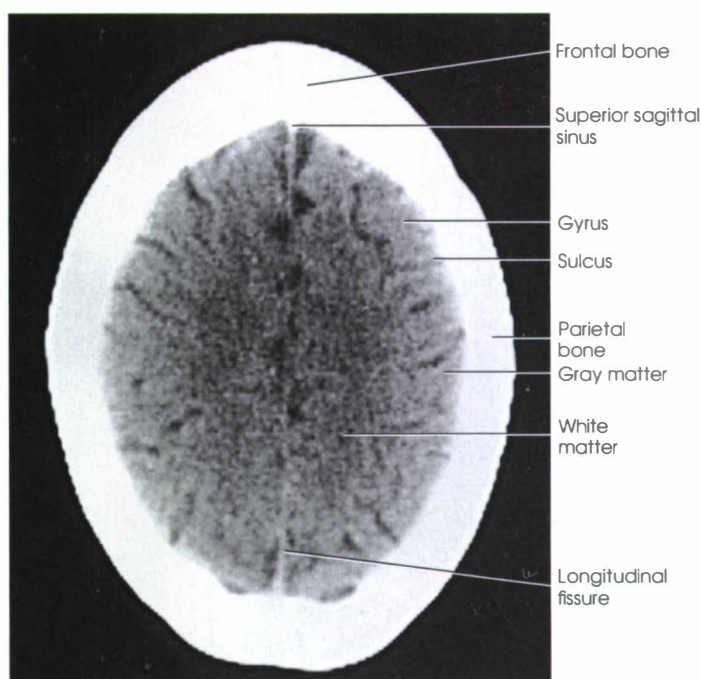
CT image representing the anatomic structures located at level A in Fig. 27-1.
